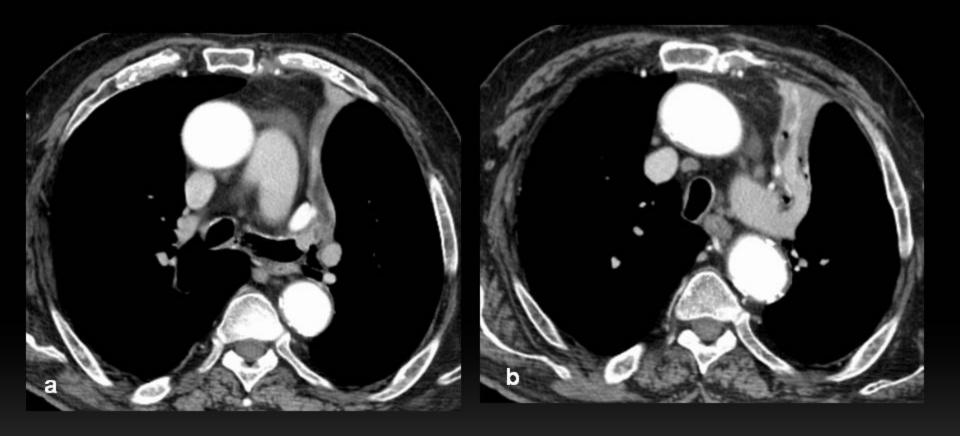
Man, 76 years old, ex-smoker and with dyspnea and hemoptysis. Thoracic CT discloses an endobronchial mass (a) conditioning collapse of the left upper lobe(b).
